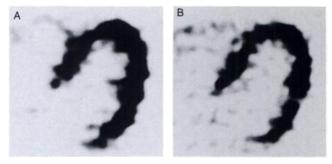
An example of transaxial images in a diabetic patient obtained during insulin clamping (A) and after acipimox in the fasting state (B) (50 min after [¹⁸F]FDG injection). Comparable image quality was obtained by both approaches.
